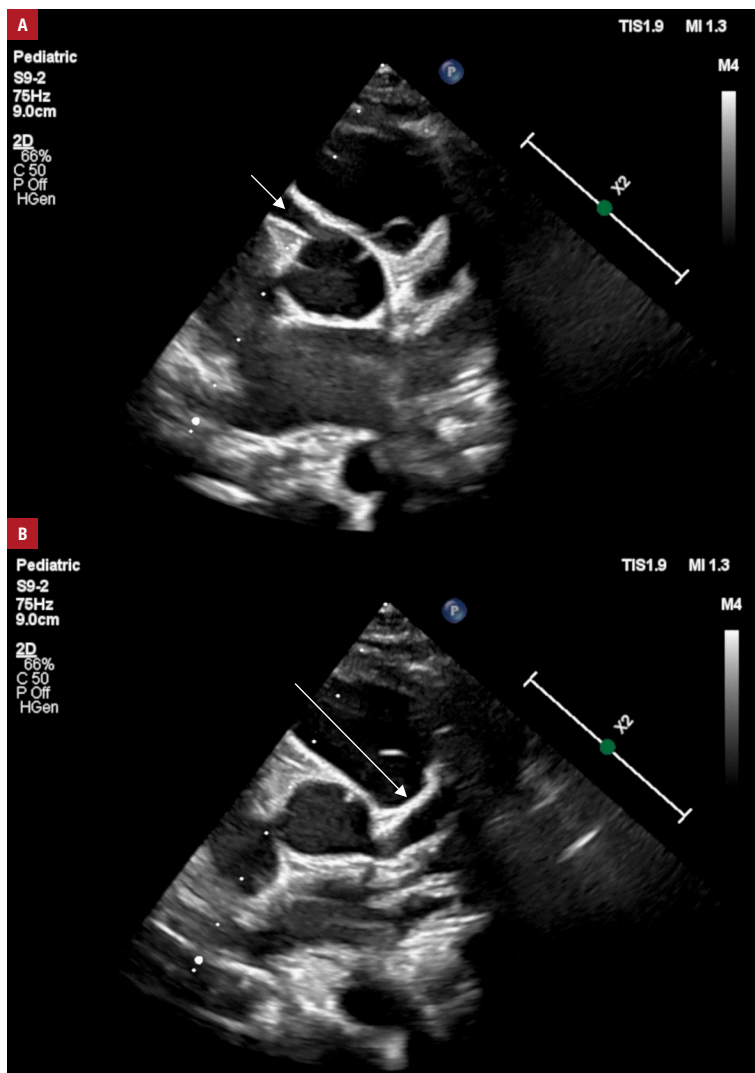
Echocardiography in a 2-year-old boy with pediatric inflammatory multisystem syndrome accompanied by giant coronary artery aneurysms: A – right coronary artery aneurysm (arrow); B – left coronary artery aneurysm (arrow)
